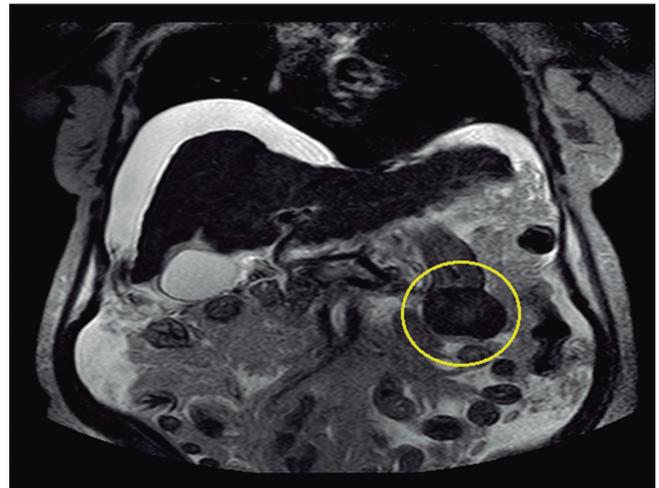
Abdominal computed tomography (T2 sequence, coronal view): a round extraluminal gastric mass can be seen (circle).
